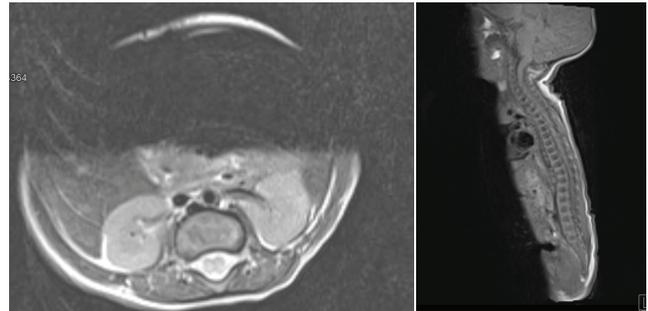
T2W MRI showing splitting of spinal cord at L3-L4 level
